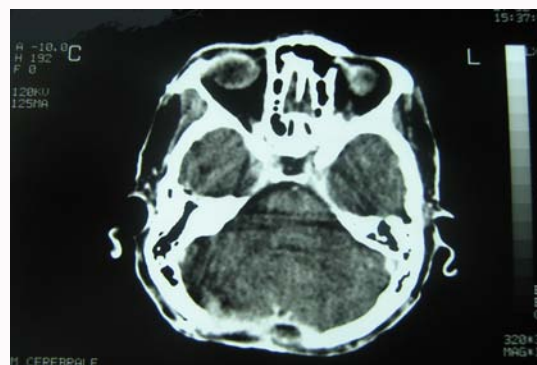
Postoperative axial CT scan showing no residual tumour and no contrast enhancement.
